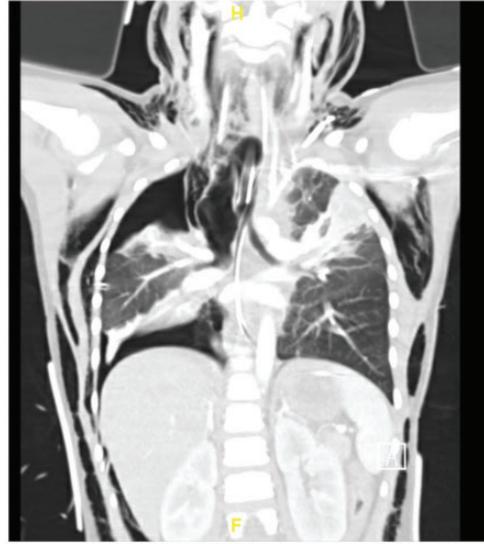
Chest computed tomography showing bilateral neck subcutaneous emphysema, right bronchial avulsion, tracheal disruption, pneumomediastinum, and a dropped right lung.
